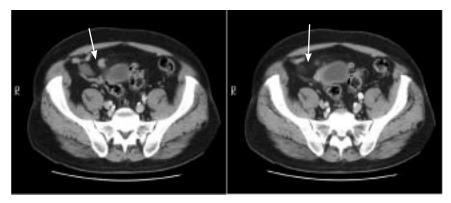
Computed tomography scan of the pelvis, showing a closely adherent appendix (arrows) and right urinary bladder wall. At left, the bladder wall appears normal, but at right, the bladder wall shows thickening.
